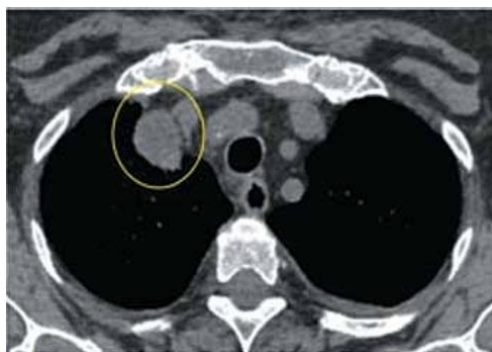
Patient T. multislice computed tomography of the chest organs dated July 28, 2022. Enlarged retrosternal lymph nodes are detected
